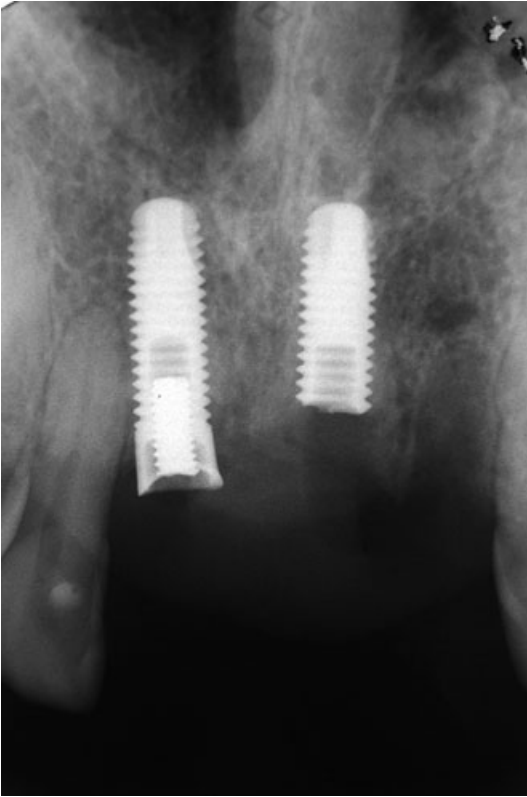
Initial periapical radiograph. Observe the presence of two damaged implants and the alveolar healing process of the tooth 22. Left implant: fractured prosthetic component with its fractured screw; right implant: fracture in the crown third of its body.
